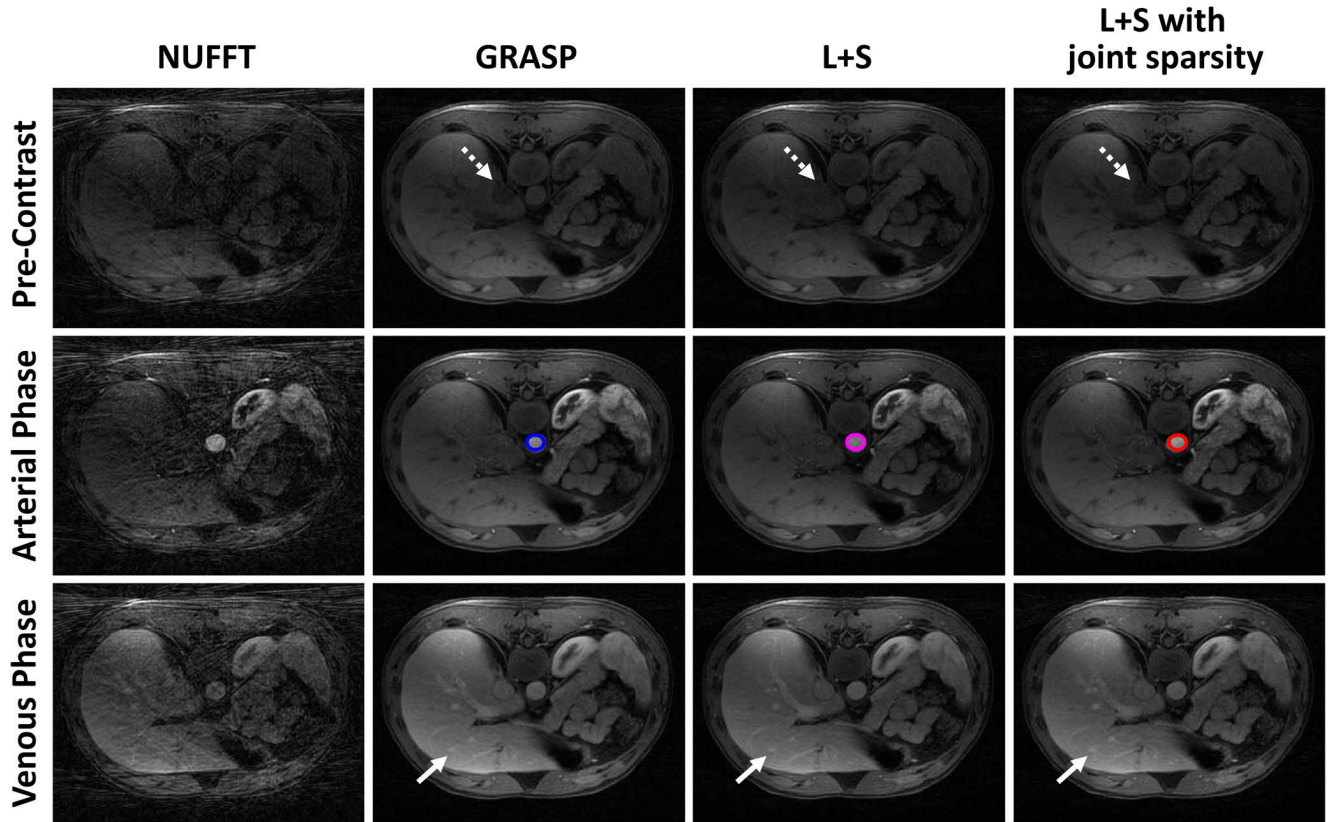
A comparison of different reconstruction schemes in the three representative phases in a liver DCE-MRI dataset at AF = 22 and 28 spokes/frame. Both the proposed method and the standard L+S method provide better background structures than GRASP. Our L+S with joint sparsity followed by Fig. 1. FCSA demonstrated better dynamic contrast (solid arrow and dashed arrow). Arterial signal intensity in the selected region (labeled by circles) among all the frames was used to estimate the dynamic contrast performance in different reconstruction schemes.
